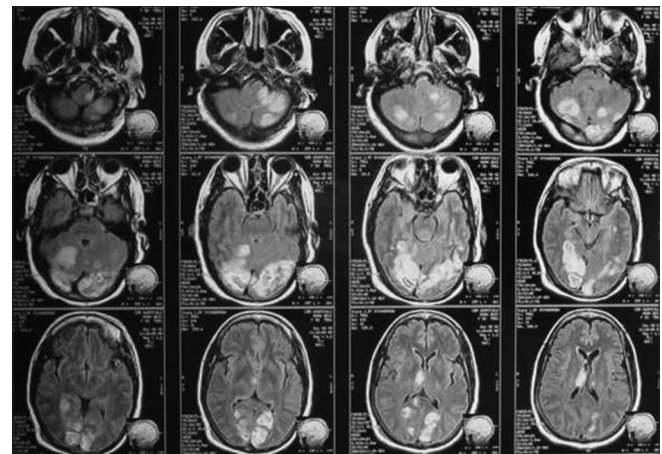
Showing magnetic resonance imaging of the brain with posterior cerebral artery infarct
